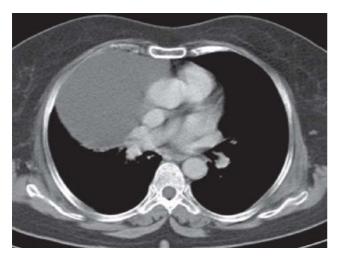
Contrast enhanced computed tomography of chest showing localised collection of fluid in the right para-mediastinum.
